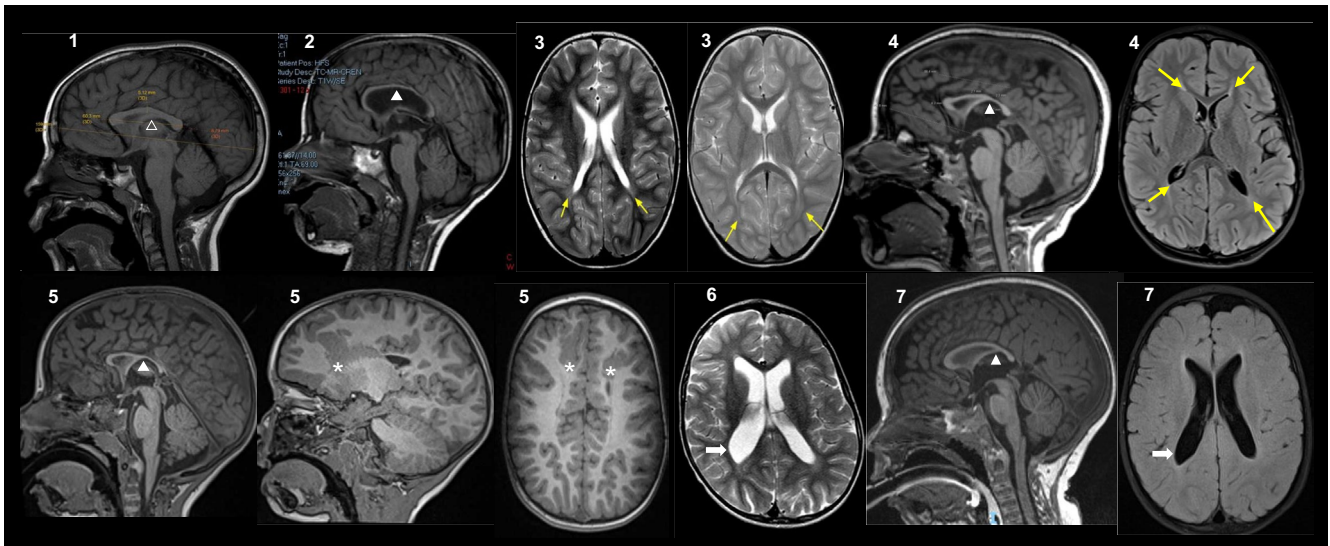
Neuroimaging findings: Brain MRI images labeled with the corresponding patient identifier. Open triangle, normal CC; solid triangle, hypoplastic CC; yellow arrows, white matter hyperintensities; *, gray matter heterotopias; white arrows, ventricular dilatation. Detailed findings provided in Table 1 and Supporting Information S1. [Colour figure can be viewed at [wileyonlinelibrary.com](https://onlinelibrary.wiley.com)]
